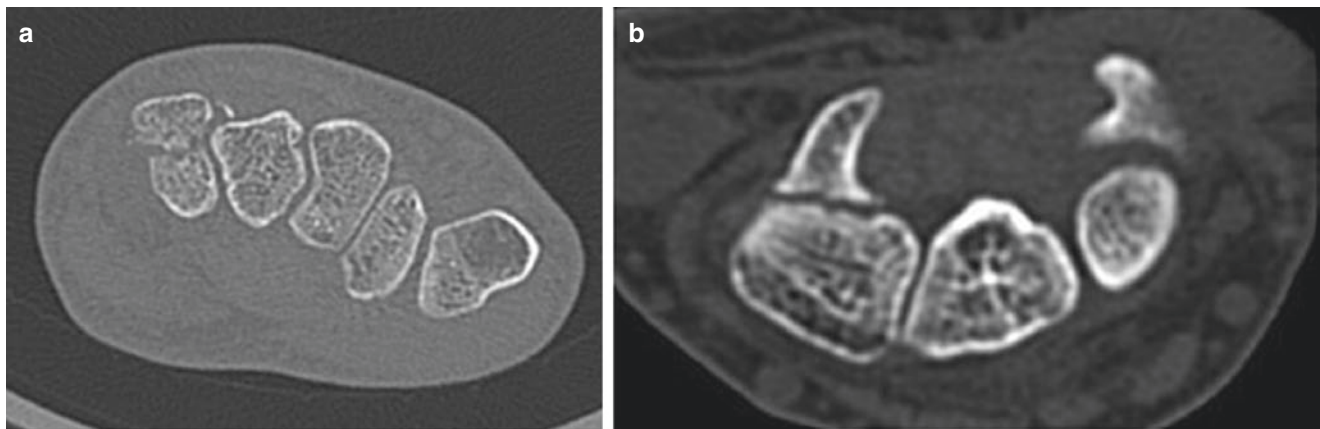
CT scans demonstrating (a) hamate body fracture and (b) hamate hook non union
